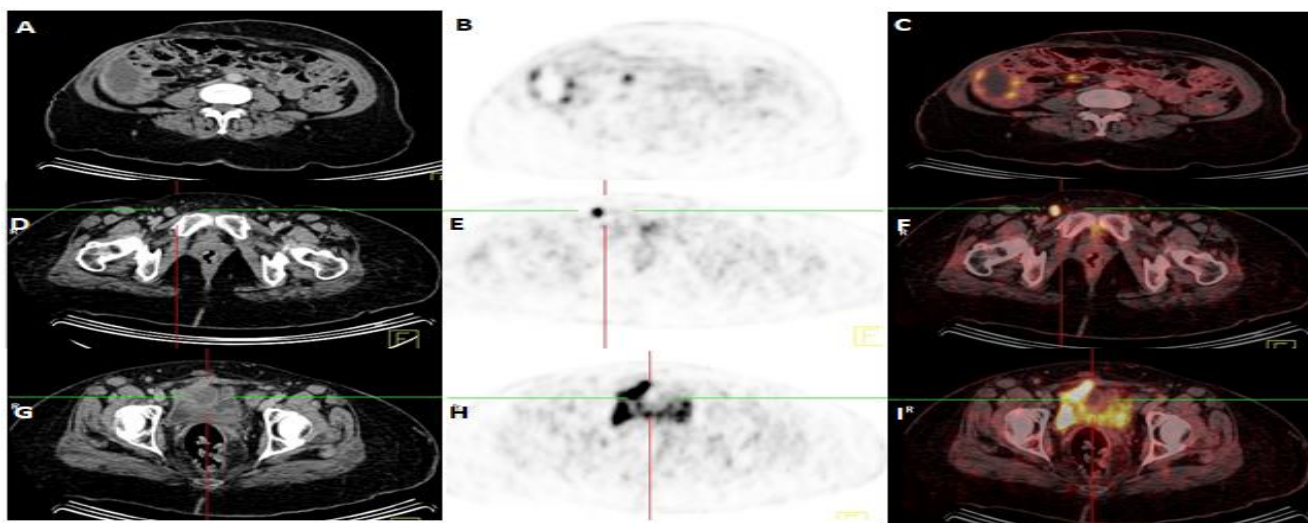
A 64yrs patient with ovarian cancer, received C/TH and referred for follow up. CECT (A, D, and G) images displayed a loculated right paracolic collection measuring 7.8x15.5 cm, small sub centimetric right inguinal LN, and a right pelvic cystic lesion with a solid component measuring 4.2x4.3 cm. PET and PET/CT scans showed diffuse FDG uptake at the loculated right paracolic collection (SUV max 8), the right ovarian mixed cystic and a solid lesion (SUV max 13). Also, FDG-avid omento-peritoneal infiltrative thickening, multiple nodularity and serosal implants (SUV max~11.2) were seen in addition to active FDG uptake at the small right inguinal LN (SUV max 5.5).
